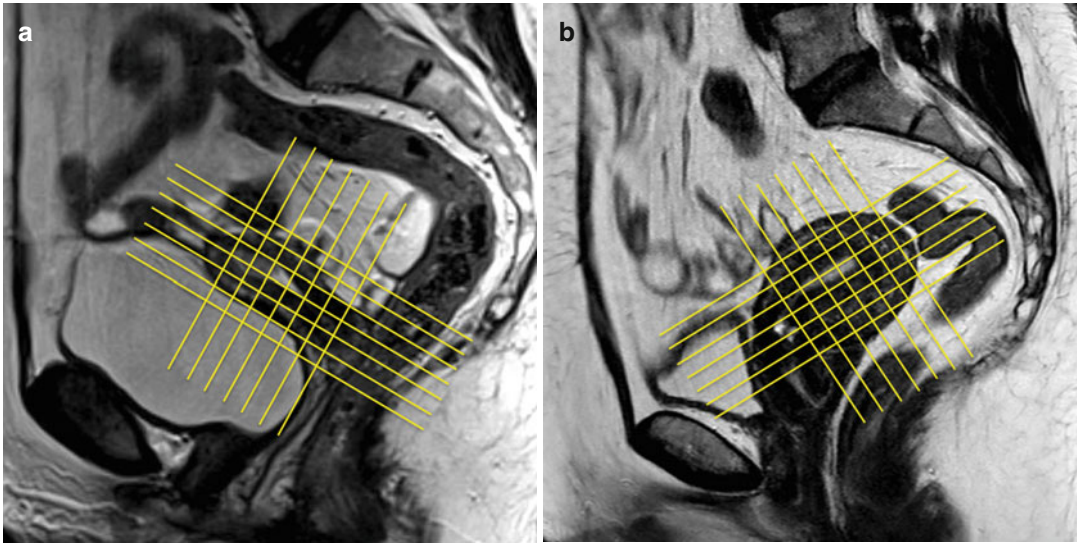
(a, b) MR scanning plans for the study of the endometrium. The *yellow lines* on these sagittal TSE T2-weighted images (TR/TE 2,400/76 ms) show the correct orientation of uterine scanning plans. In order to avoid possible staging errors, MRI scanning planes must
